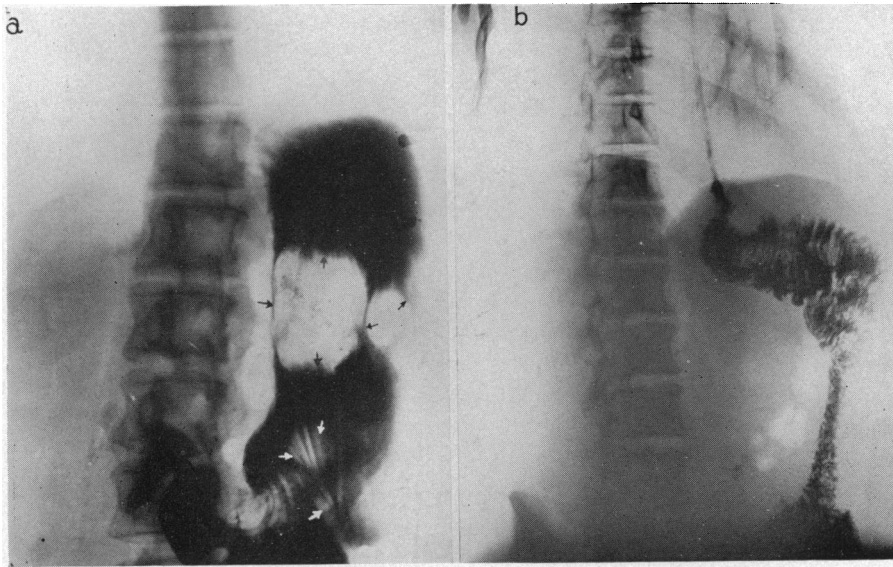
Case 2: (a) Roentgenogram of the stomach showing the tumor masses occupying most of the stomach. (b) A postoperative roentgenogram showing the jejunum anastomosed to the esophagus. Note the long antecolic loop of jejunum without an entero-enterostomy, and how well it functions.
